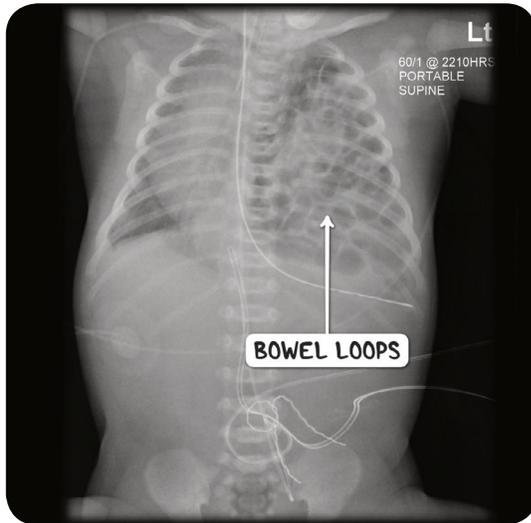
A plain X-ray of a newborn demonstrating visible bowel loops in the thoracic cavity.
